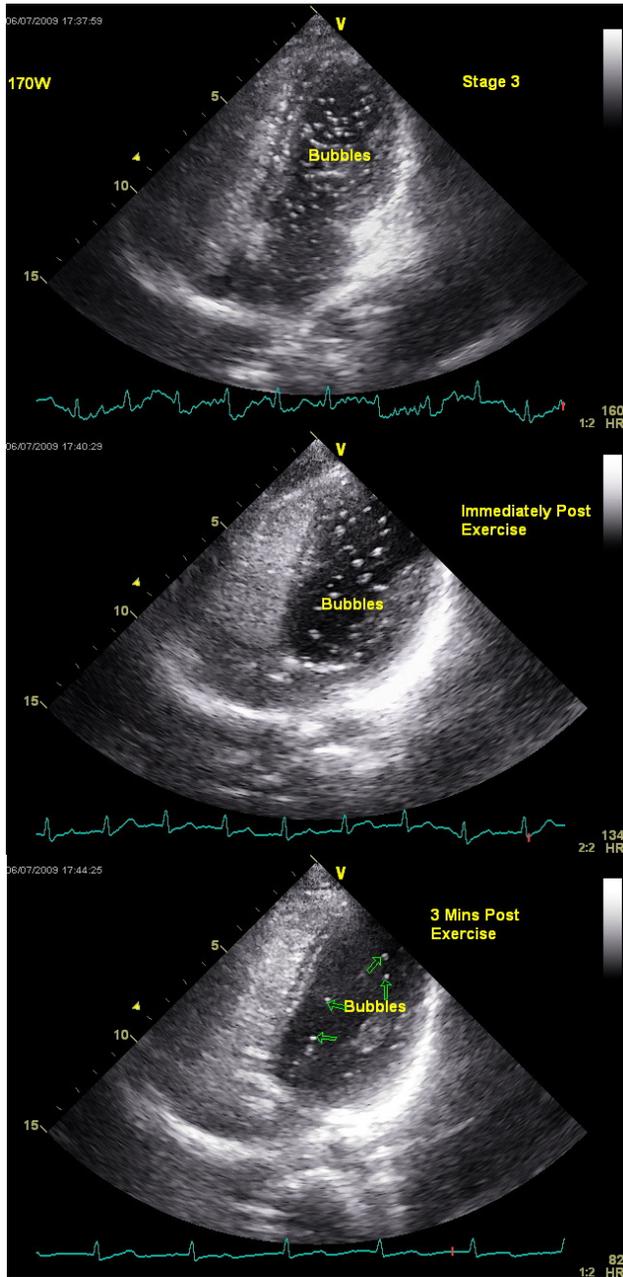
is an apical four-chamber view of subject 11 in Stage 3, immediately post-exercise and three minutes post-exercise. All three images demonstrate that an IPAVS is present as there are contrast bubbles in the left side of the heart after more than three cardiac cycles.
